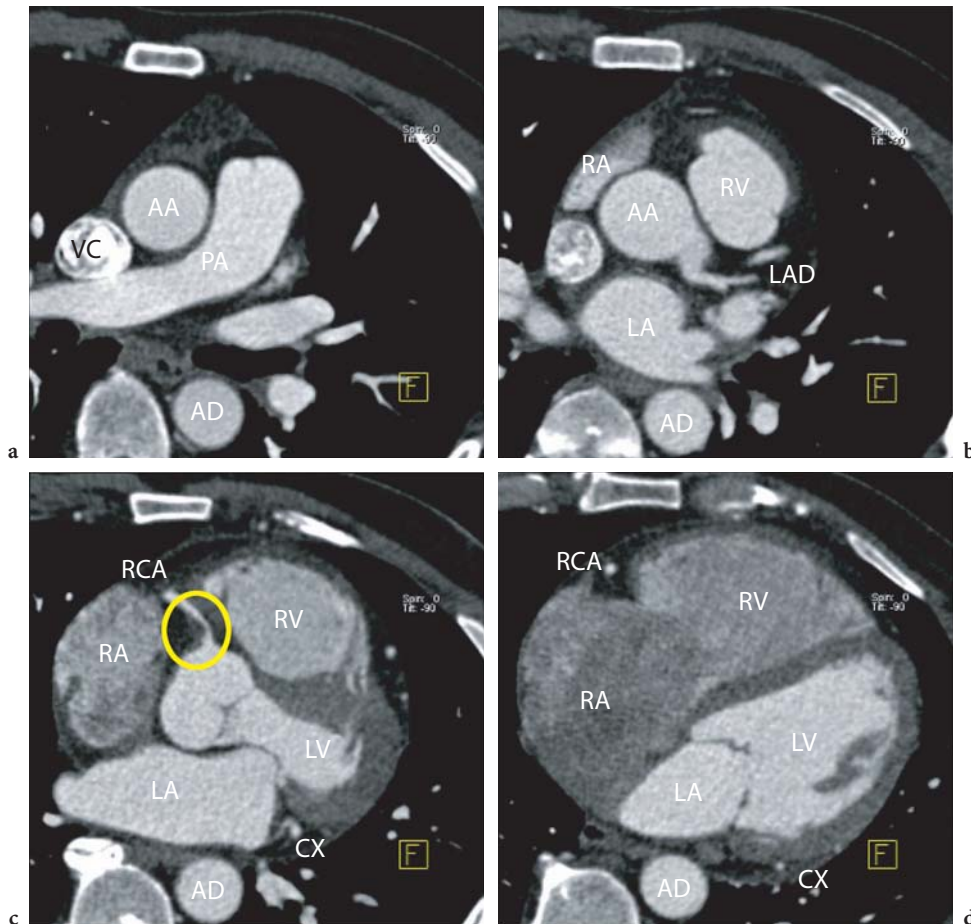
Axial images at different anatomical levels (a–d, in craniocaudal direction) of a coronary CT angiography examination in a patient with a stenosis in the right coronary artery (yellow circle). The images were acquired using a 64-slice CT scanner with 64×0.6 -mm slices per rotation and 0.75-mm slice width. Axial images include all of the information acquired in a CT scan and should be reviewed in any case, e.g., by scrolling through them. For better orientation, important anatomical landmarks have been labeled. AA Ascending aorta, PA pulmonary artery, AD descending aorta, VC vena cava, RA right atrium, RV right ventricle, LA left atrium, LV left ventricle, LAD left anterior descending coronary artery, RCA right coronary artery, CX circumflex artery. (Case courtesy of Erlangen University, Germany)
